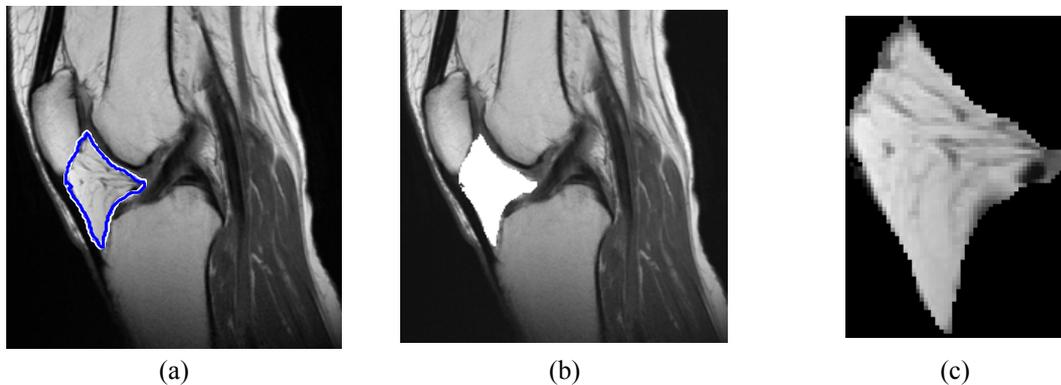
The gray scale image which would be used in the MATLAB program. The blue line represents the trace which the user to input. The b panel shows ROI removed from 2D MRI slice. The C panel shows infrapatellar fat pad which was removed from the slice to measure its area
